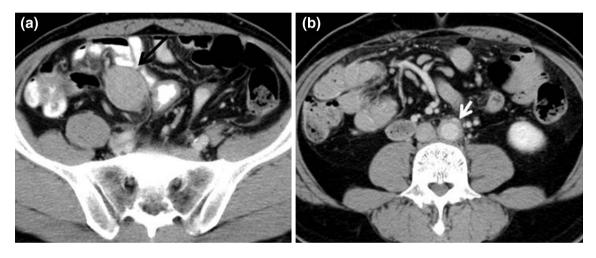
Abdominal CT shows a 6-cm soft tissue mass (*long arrow*) in the right lower mesentery (\mathbf{a}), and multiple enlarged lymph nodes and mild soft tissue mass encasing the aorta (*short arrow*) (\mathbf{b})
